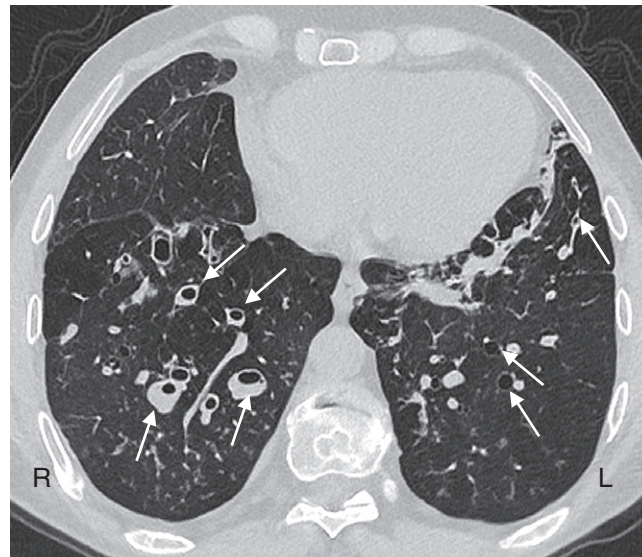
Bronchiectasis. Chest CT demonstrating bilateral lower lobe bronchiectasis, more severe in the right lung base. The arrows indicate dilated bronchi which, on the right, are associated with bronchial wall thickening.
